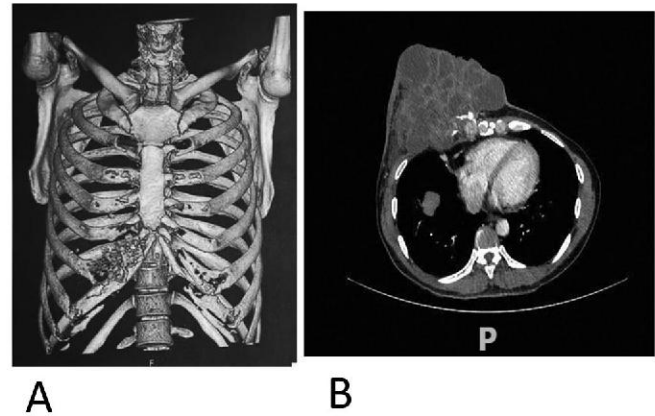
CT scan of the chest with IV contrast: (A) 3D reconstruction of anterior chest wall demonstrating lytic destruction of the underlying 2nd to 6th costal cartilage; (B) A large lobulated ulcerating mass with calcifications in the right breast, measuring approximately 17.5 cm x 16.3 cm x 13.5 cm, extending into the subjacent pleural space.
